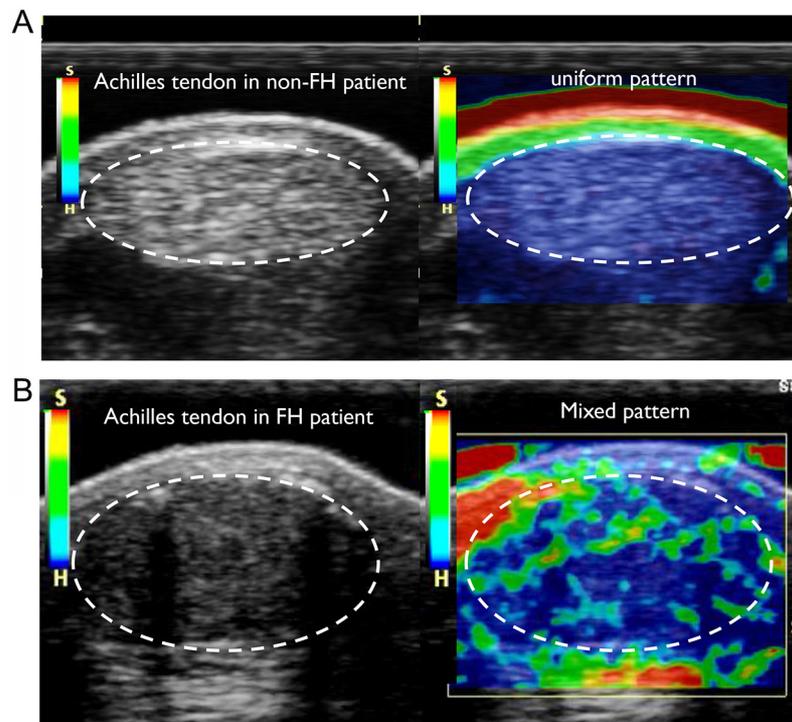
Achilles tendon Ultrasonogram and Elastography. (A) Ultrasonogram and elastogram of the Achilles tendon for a 48-year-old male non-FH patient; (B) Ultrasonogram and elastogram of the Achilles tendon for a 24-year-old male FH patient.
